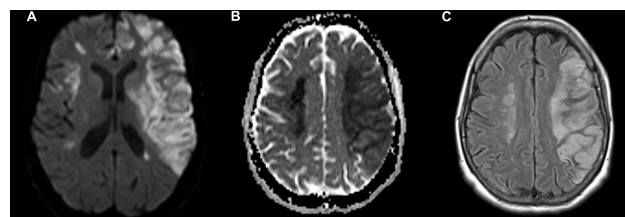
Brain magnetic resonance imaging (MRI), axial view. (A) hyperintense signal in diffusion weighted sequence showing restriction in diffusion in the territory of both middle cerebral arteries. (B) Apparent diffusion coefficient (ADC) map with hypointense signal showing diffusion restriction in the territory of both middle cerebral arteries. (C) Flair sequence with hyperintensity in the territory of both middle cerebral arteries.
